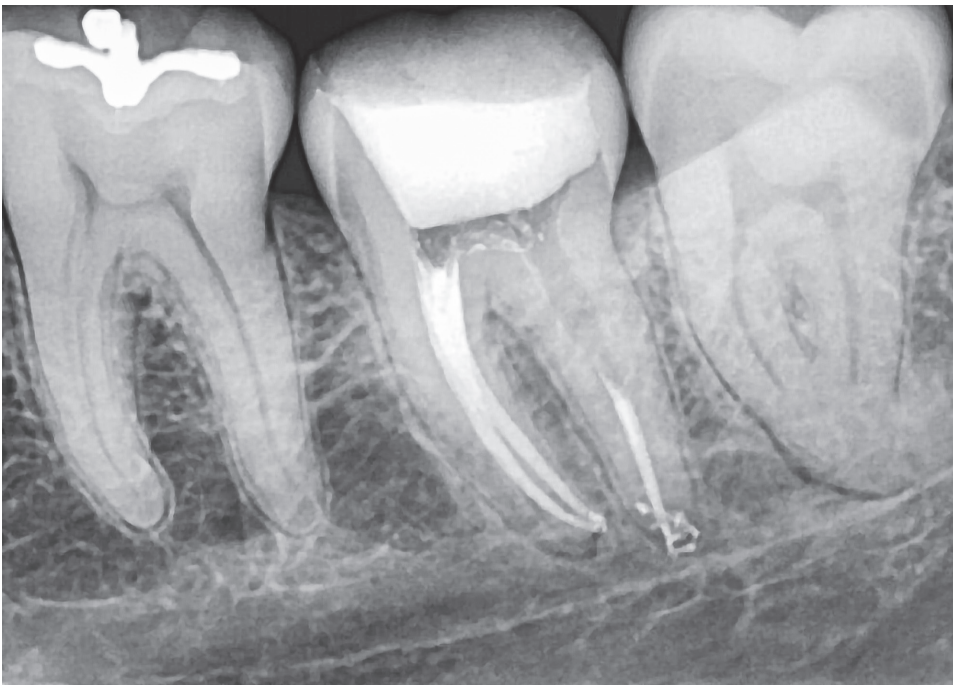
Final radiograph after root canal filling and post space preparation in the distal root.
